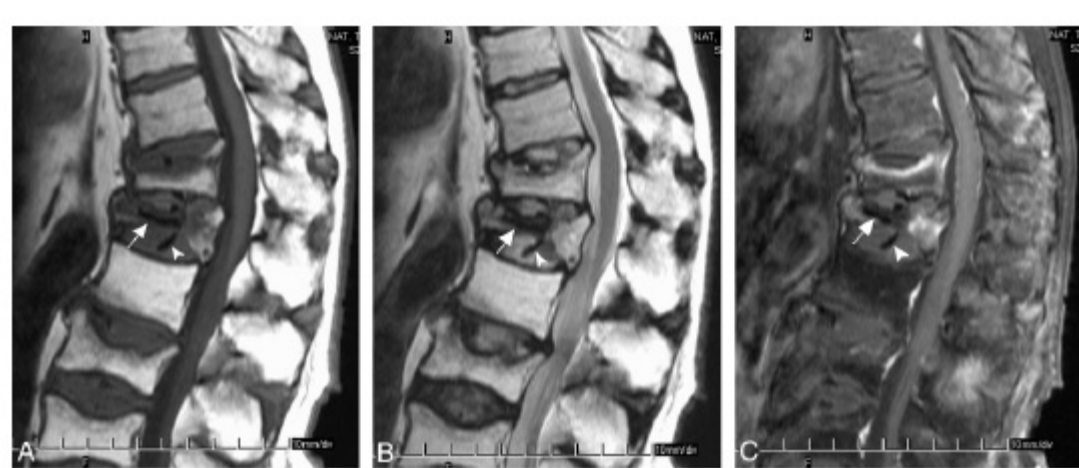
MR images and plain radiograph of a 73-year-old man who had compression fractures at T12, L1, L3, and L4 vertebral bodies and osteonecrosis at L1 vertebral body. There is intravertebral air in the severely collapsed T12 vertebral body and also intradiskal air in the adjacent T11–T12, T12–L1, and L1–L2 disks. In the center of the collapsed vertebral body is a horizontally oriented signal intensity void line (white arrows, panels A–C) on all pulse sequences. Also, several signal intensity void dots or rods in the adjacent disks (above and below) are shown on all pulse sequences (white arrowheads, panels A–C). *A*, Sagittal T1-weighted turbo spin-echo image (600/12, 4-mm section thickness) shows hypointensity in the most of the vertebral body; only the posterior fifth is relatively spared. *B*, Sagittal T2-weighted turbo spin-echo image (4000/120) shows some hypointensity at anterior four fifths of the collapsed vertebral body. *C*, Sagittal contrast-enhanced T1-weighted, fat-suppressed turbo spin-echo image (890/12, 4-mm section thickness) shows nonenhancement portion at middle three fifths of the collapsed vertebral body. *D*, Lateral view of plain radiograph shows severely collapsed vertebral body with a short and horizontally oriented air cleft at the anterior second fifth of the vertebral body (white arrow).
